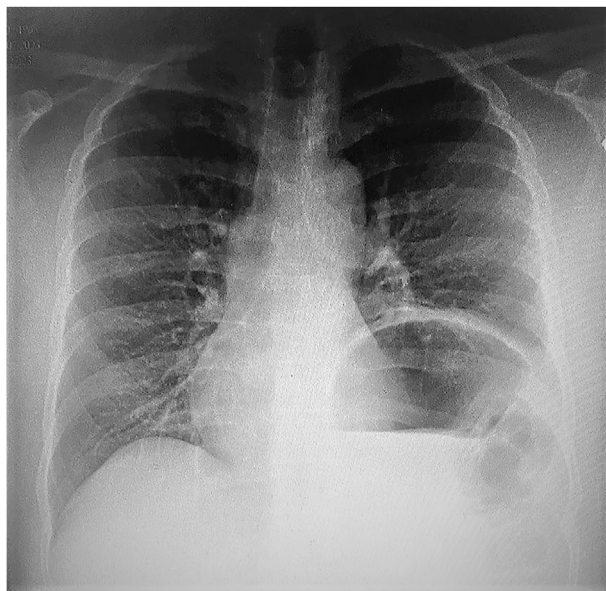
Chest radiograph demonstrates eventrated left hemidiaphragm.
